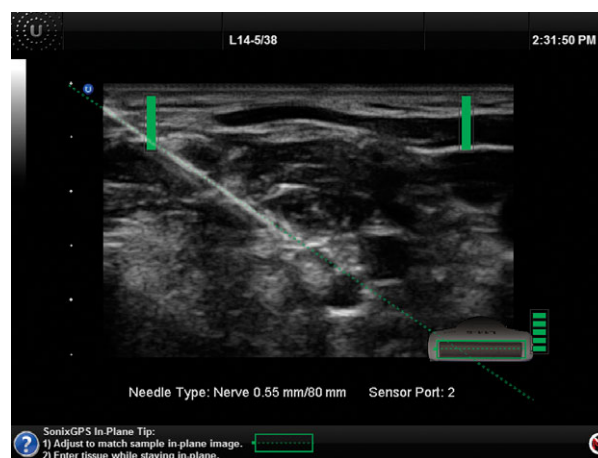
Example of an interface of an electromagnetic tracking system. Example of the predicted needle trajectory using an in-plane technique. In the right bottom of the screen, the orientation of the needle relative to the US probe is shown (Image courtesy of BK Ultrasound, Richmond, BC, Canada).
